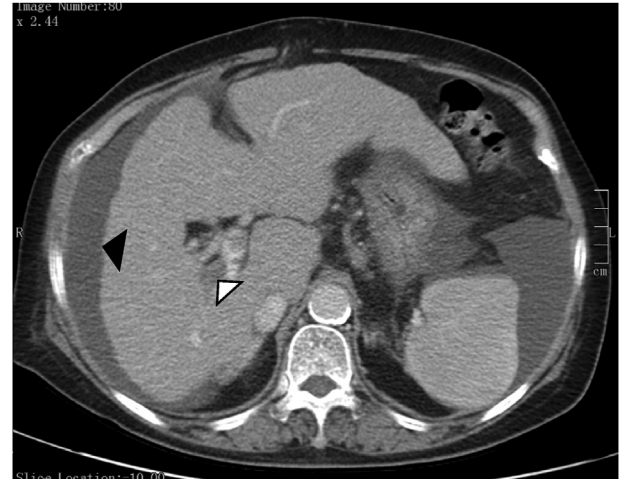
CT image showing thrombosis in the portal vein (white arrowhead) with marked ascitic fluid collection (black arrowhead) surrounding the liver.
